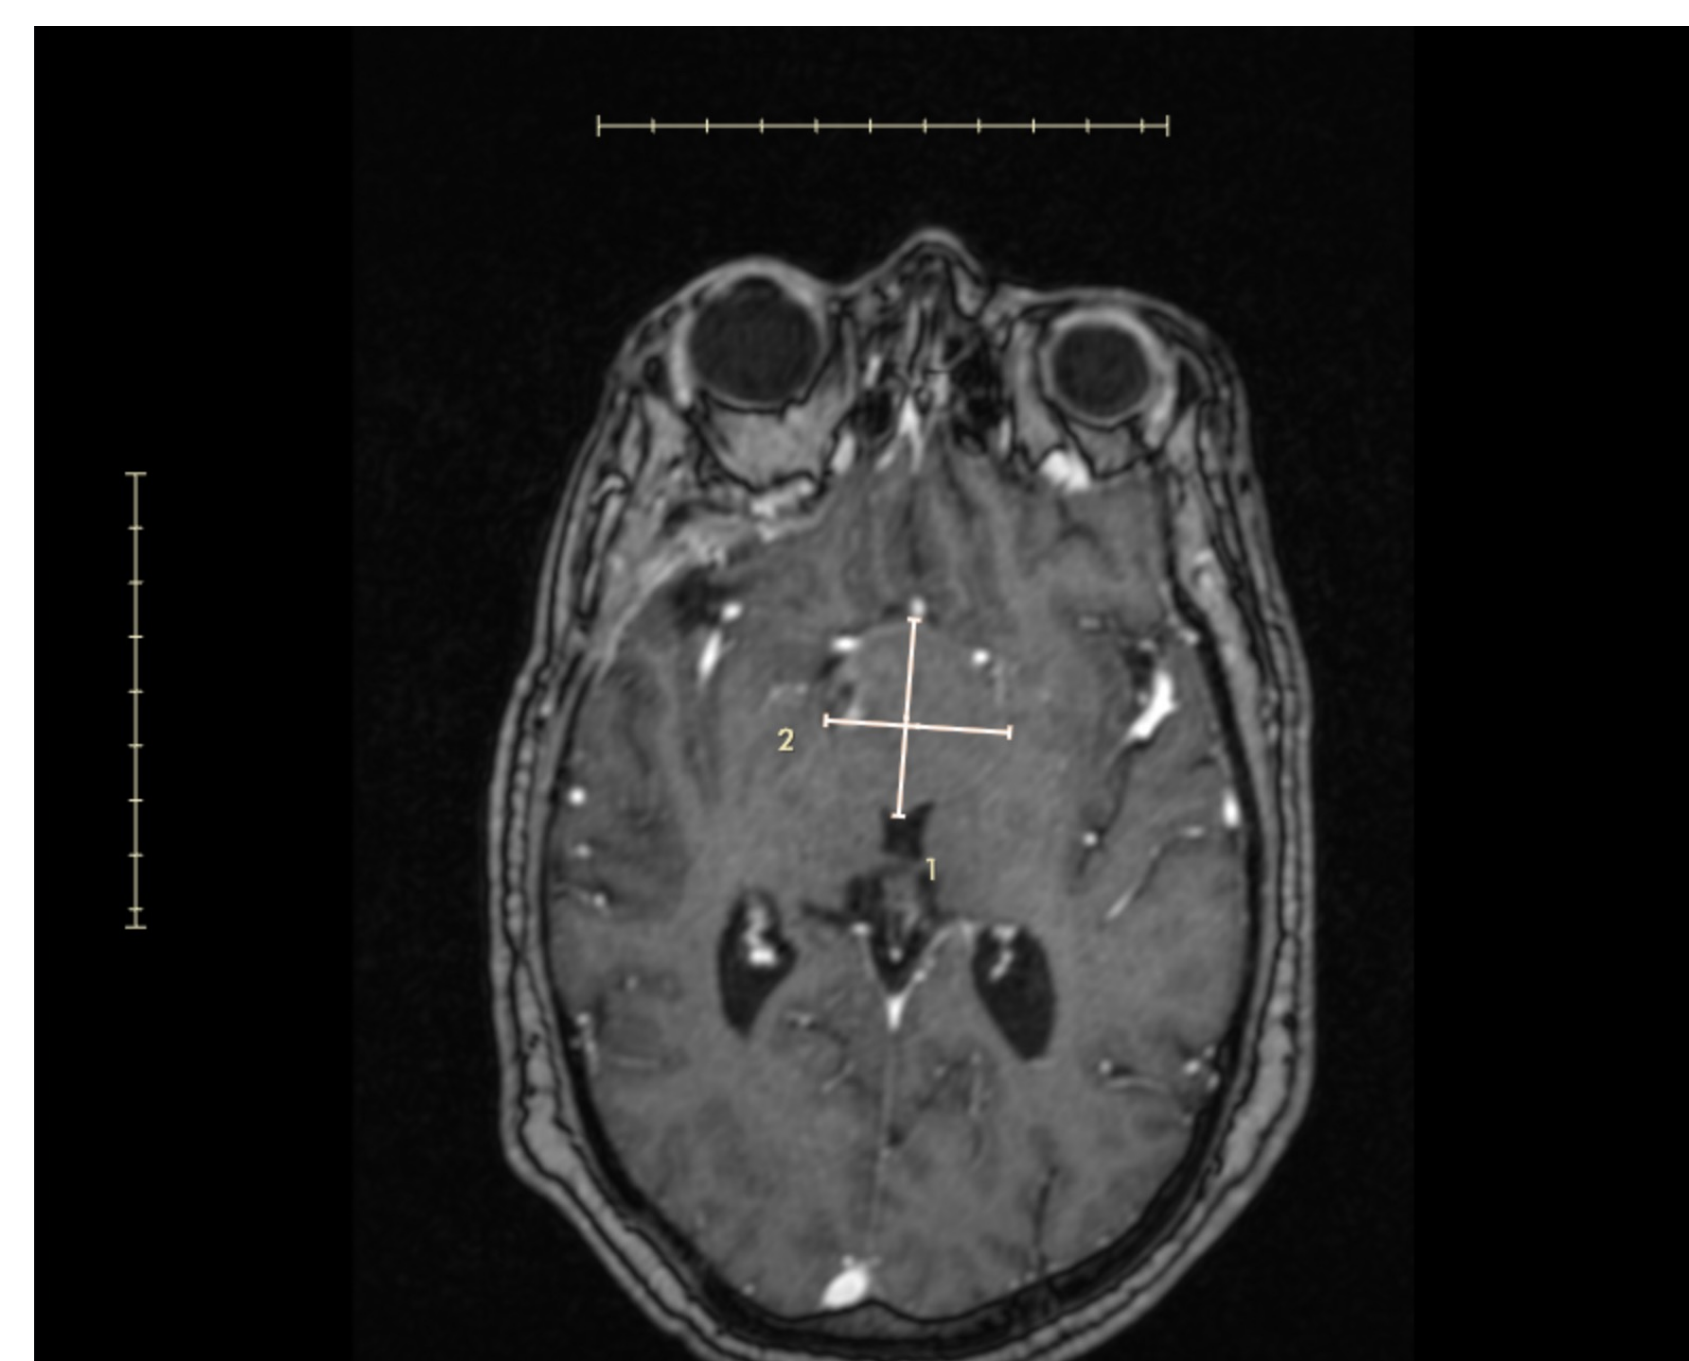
Axial brain MRI depicting cholesterol granuloma
